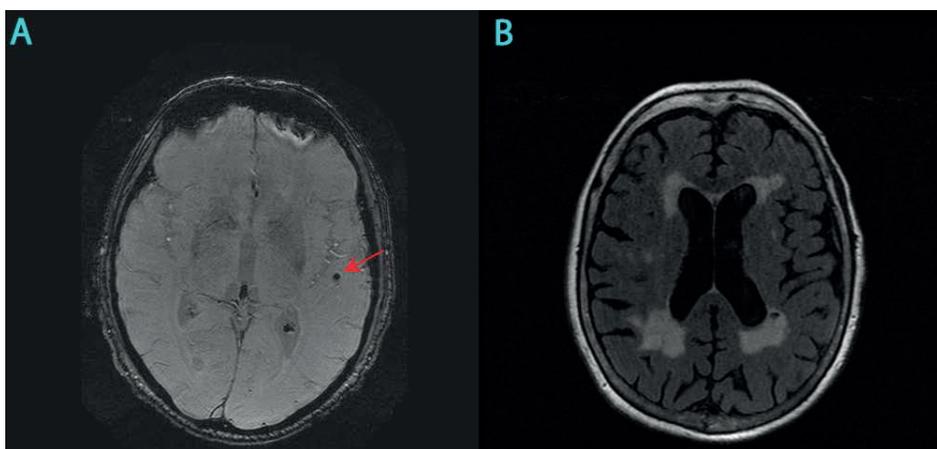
A) Axial slice of a susceptibility weighted image (SWI). The red arrow indicates a microbleed. B) Axial slice of a T2-weighted fluid attenuated inversion recovery (FLAIR) image on which white matter hyperintensities are visible. Images were obtained by means of a 1.5 tesla MRI scanner.
